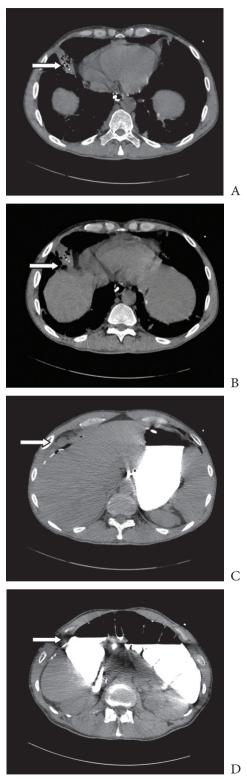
CT enterography. Colobronchial fistula tract (arrows) coursing from hepatic flexure and extending on the liver anteriorly and eventually communicating to right lower lobe bronchus with surrounding lung consolidation. Figures A and B demonstrate gastrointestinal contrast in the lung parenchyma. Figures C and D show fistula tract containing contrast from colon over the right lobe of the liver
